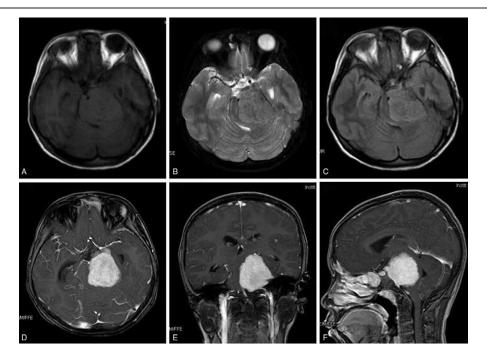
(A) Axial T1-weighted MRI showing a hypointense mass with severe compression of the brainstem in the left petroclival region. (B) Axial T2-weighted and (C) axial fluid-attenuated inversion recovery MRI showing the lesion as hyperintense. (D, E, F) Axial, sagittal, and coronal T1-weighted contrast-enhanced MRI showing the hyperintense petroclival lesion with extension into the left cavernous sinus. MRI = magnetic resonance imaging.
